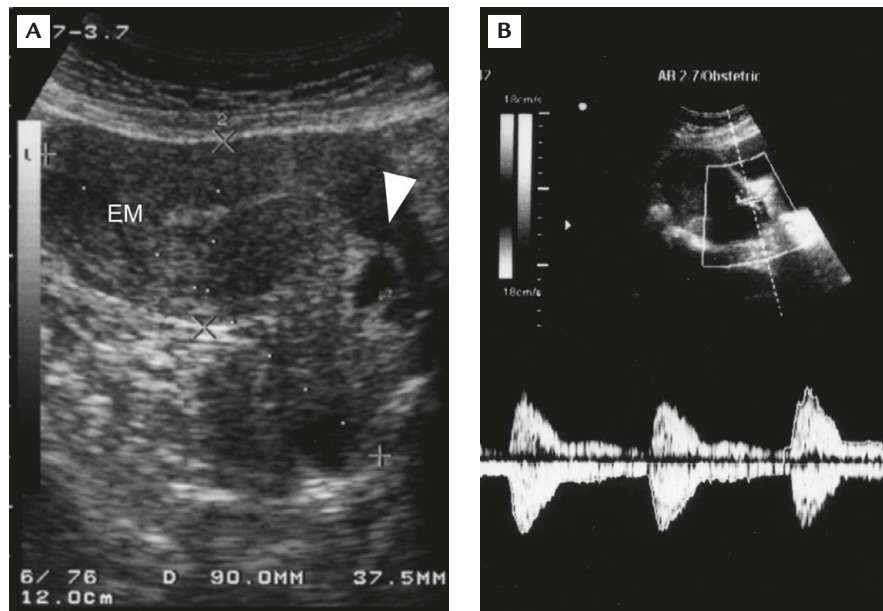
(A) The endometrial (EM) cavity is empty and a gestational sac with positive fetal heart beat is located in the endocervical canal. (B) Doppler sonography detects the vascular flow in the gestational sac in the posterior wall of cervix.
